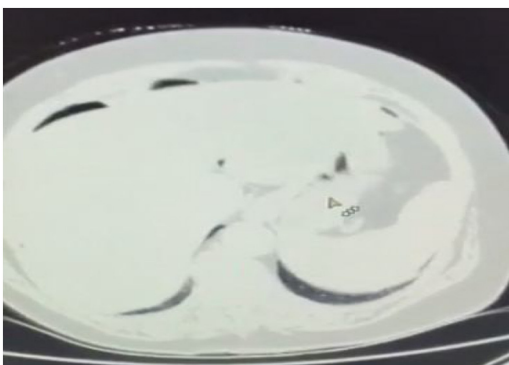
Pneumoperitoneum at computed tomography with lung window, showing perforation of the cecum.
